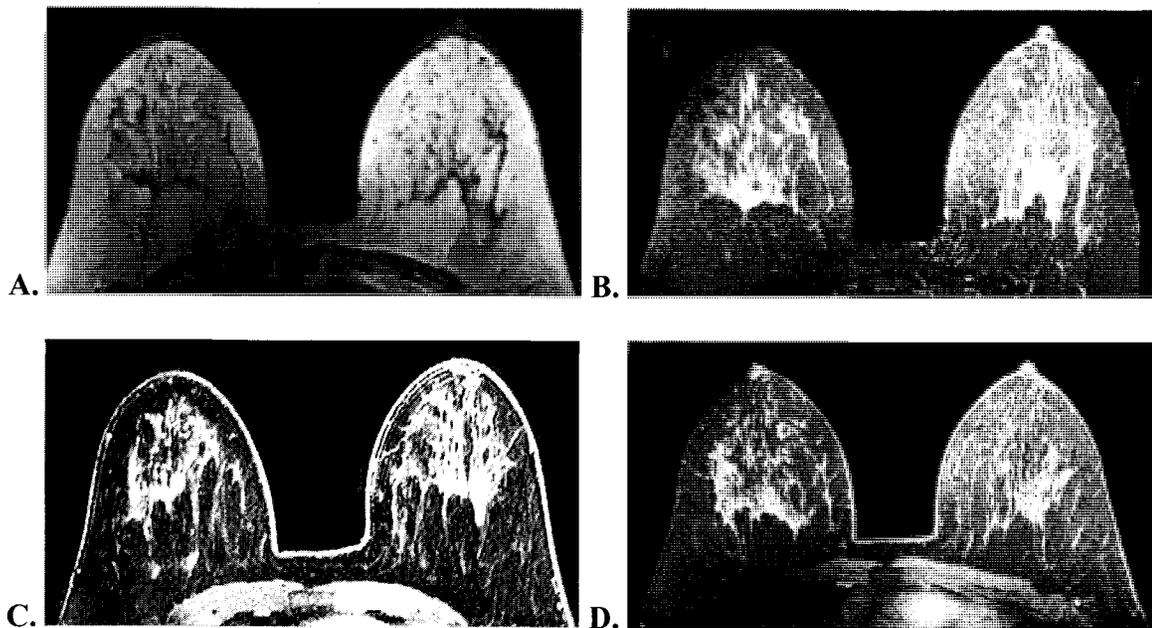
Patient 1 images from each scan performed. A) is slice 34 from the T1-weighted scan. B) is slice 34 from the T2 SPAIR scan. C) is slice 317 from the Dynamic Thrive scan. D) is slice 116 from the Thrive Post scan.
